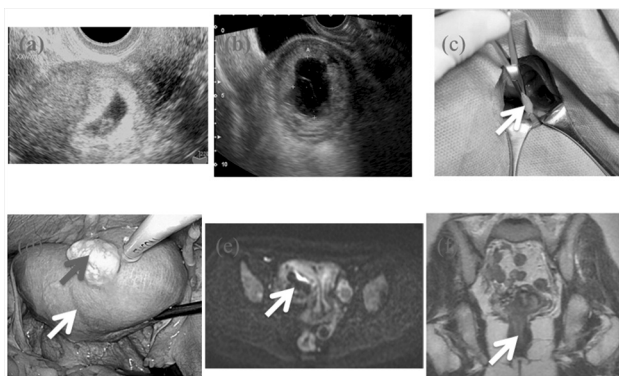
(a) First gestational sac (GS) in the uterus, where a fetal heartbeat is detected. (b) The second GS is empty. (c) The white arrow indicates the vaginal septum. (d) Laparoscopic image: the white arrow indicates the boundary of two uteri and the red arrow indicates a uterine myoma. (e) MRI of the pelvic cavity showing two uteri. The white arrow indicates a hematoma in the uterus. (f) MRI of the pelvic cavity. The white arrow indicates the vaginal septum.
